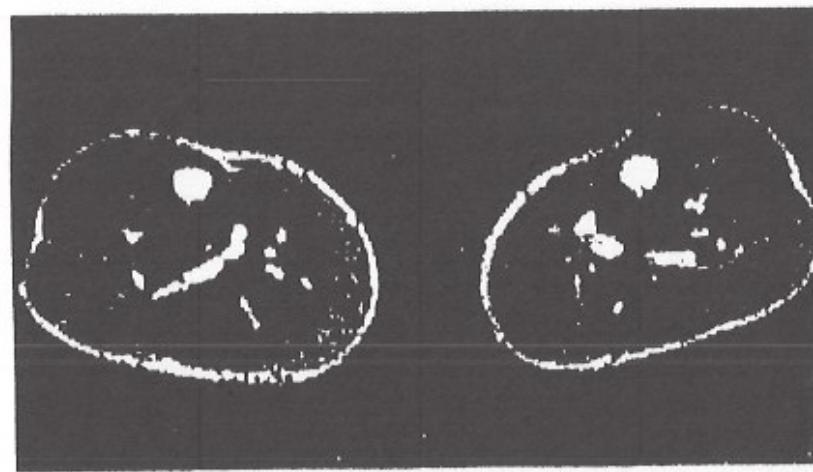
Case 2: MRI of the lower legs (TR 1600 msec/TE 120 msec, before therapy). Markedly increased signal intensities in the medial head of the right gastrocnemius muscle (left side of the figure).
